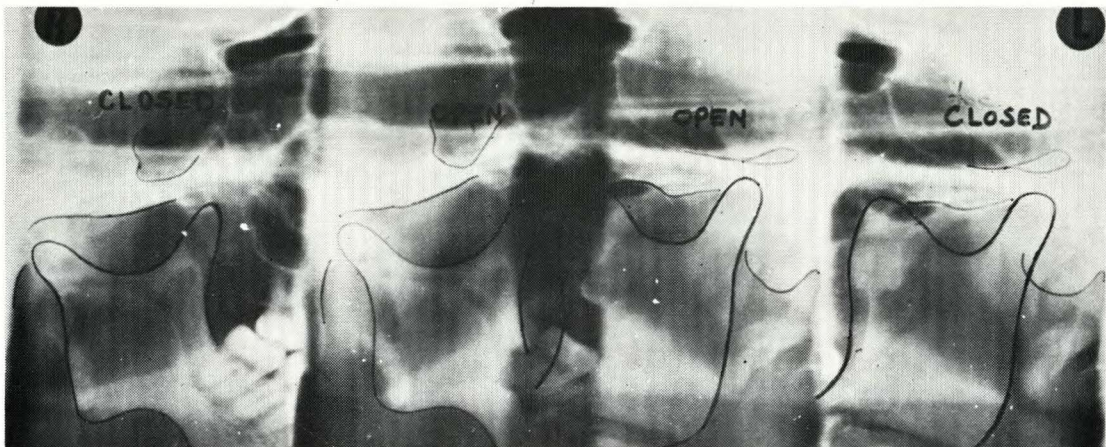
Temporo-mandibular joint radiographs
